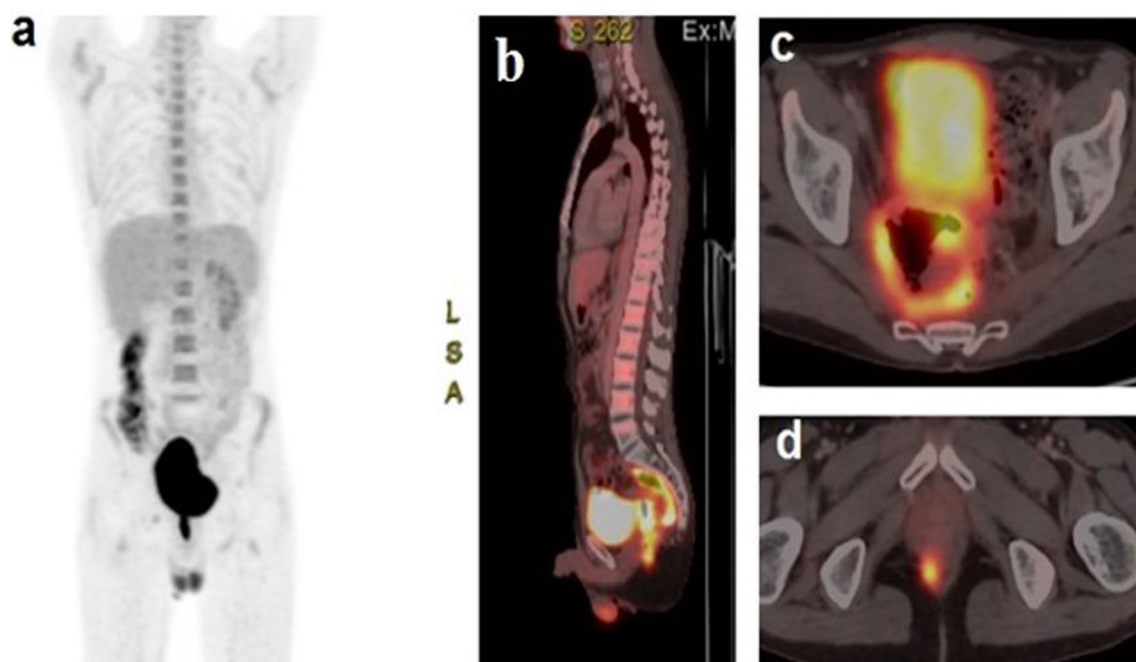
a–d follow-up PET/CT study for the same patient in Fig. 7. a MIP and b–d fused PETCT images revealed progression in size and metabolic activity of the previously noted metabolically active (FDG avid) circumferential polypoidal mural thickening involving the entire length of the rectum and rectosigmoid junction measuring about 2.2 cm at max thickness and 13 cm at max length with max SUV R 22.8 (compared to 17.26 previously). The lesion now extends to the anal canal *blending* with the previously noted right sided anal soft tissue nodule. It is seen that intimately related to the posterior wall of the urinary bladder with no definite signs of invasion. Low grade metabolically active right inguinal lymph node is still seen unchanged measuring about 1 cm with max SUV R 3.07
